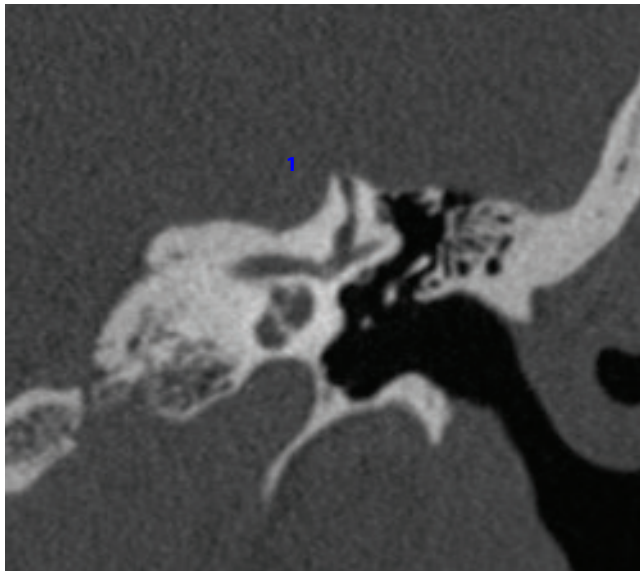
Coronal CT scan of the left temporal bone showing superior semicircular canal dehiscence (1).
